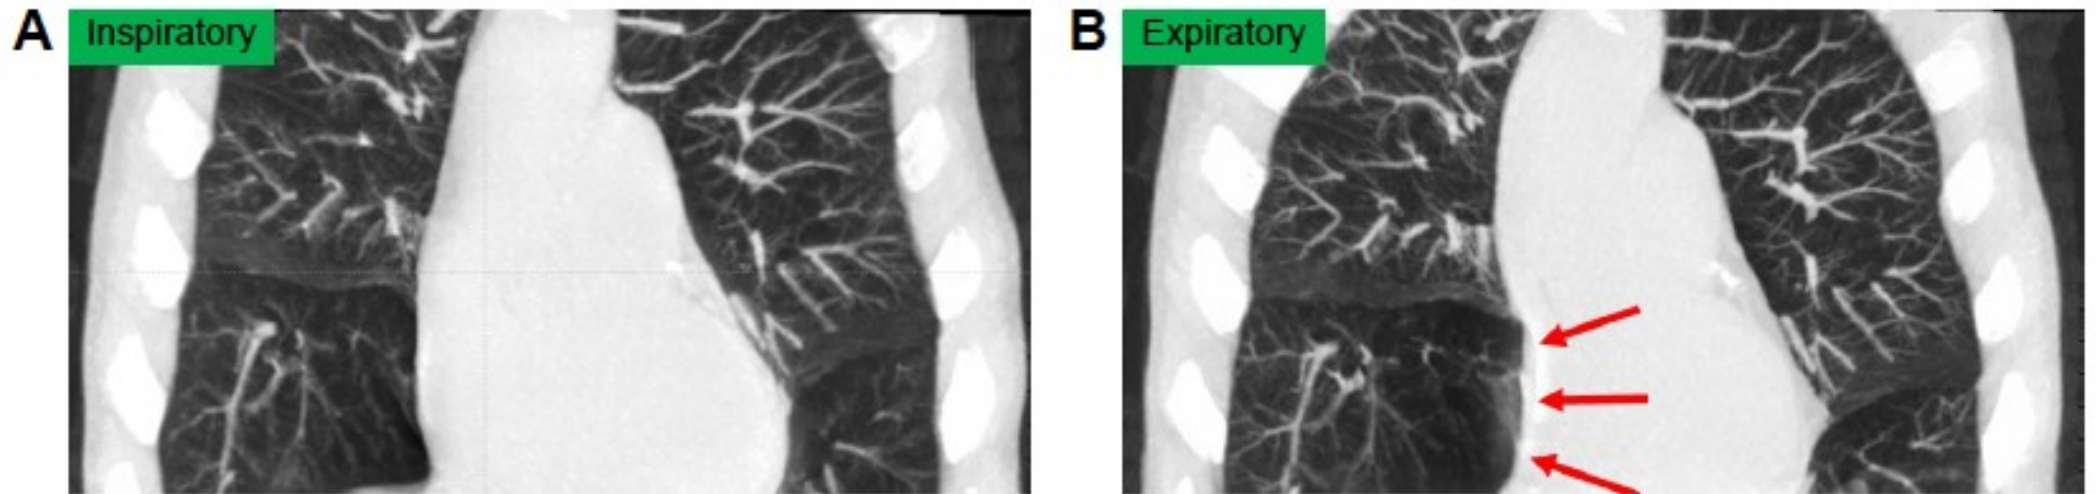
A 70-year-old male with COPD underwent dynamic-ventilation CT to evaluate central airway abnormalities.
